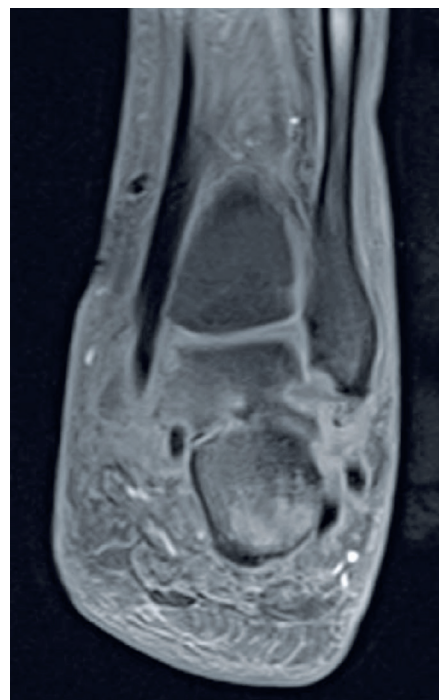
Coronal view magnetic resonance imaging scan. Talus bone exhibiting increased signal intensity, more prominent post-gadolinium, suggesting osteolysis. Calcaneus bone displaying increased signal intensity, more evident post-gadolinium, with erosion of its superior margin at the sinus tarsi, suggesting osteolysis.
